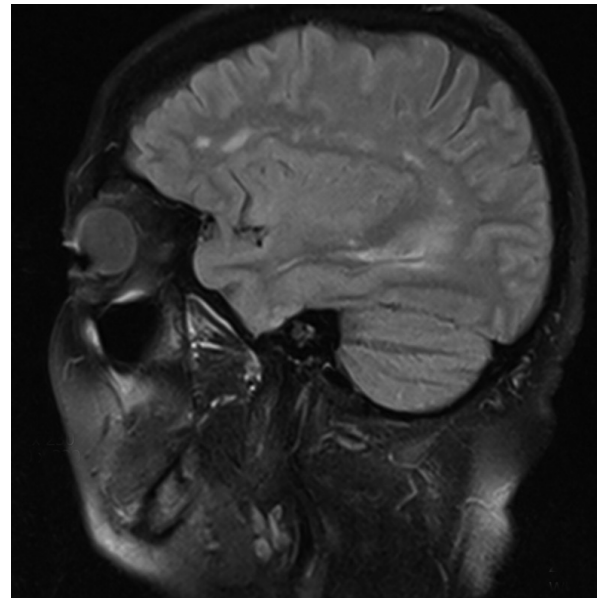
Case 3. T2-weighted images of non-specific, white matter lesions that do not fulfil neuroimaging criteria for MS diagnosis
